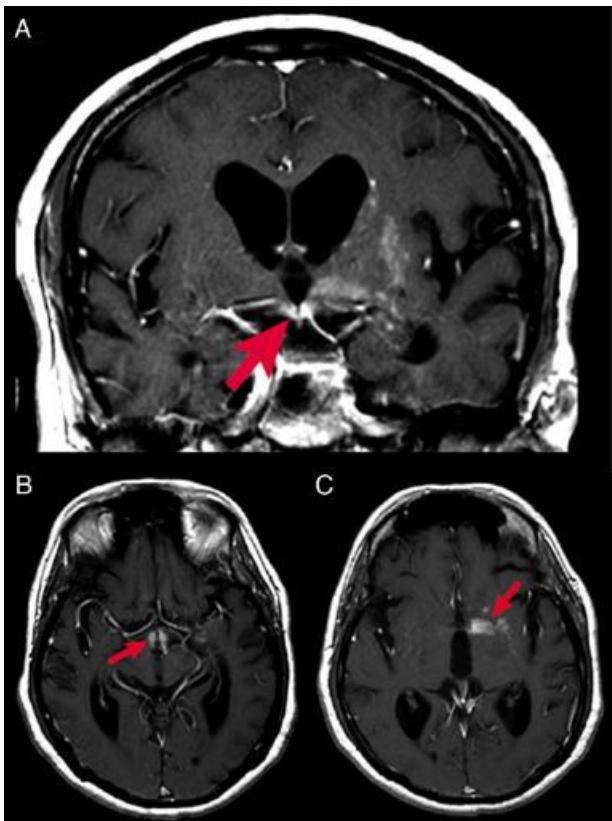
A, T1-weighted, coronal magnetic resonance imaging reveals contrast-enhancing lesions bilaterally in the ventral hypothalamus (red arrow). Additional contrast-enhancing lesions extend from the left hypothalamus into the basal forebrain, striatum, and temporal lobe. B, Axial views of this contrast-enhancing lesion in the bilateral hypothalamus (red arrow) extending superior-laterally (C) into the left basal forebrain and striatum (red arrow).
